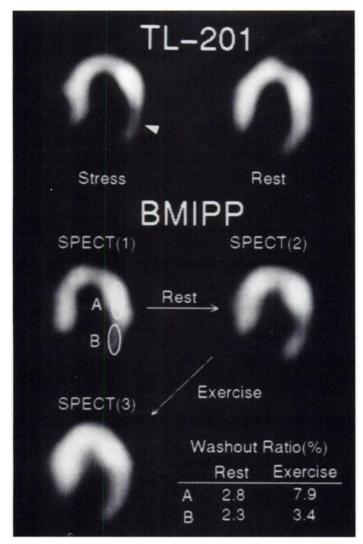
Thallium-201 and ¹²³I-BMIPP myocardial SPECT images of a 64-yr-old woman with angina. In the posterolateral wall (B), ischemia is demonstrated on a ²⁰¹TI image (white arrowhead), but the WR of BMIPP does not increase relative to normal segments (A) after exercise. SPECT (1), SPECT (2) and SPECT (3) denote images obtained before rest, before exercise and after exercise, respectively.
